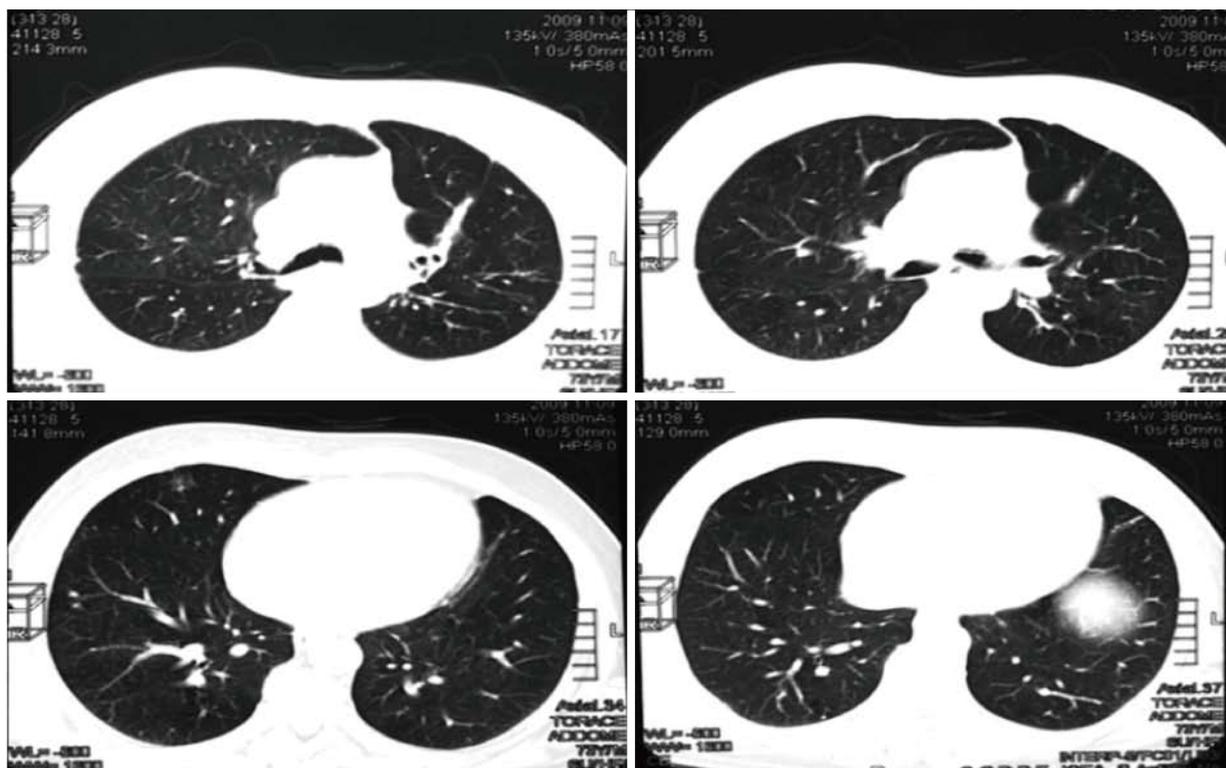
Thorax computed tomography-scan after two months of maintenance treatment. Note a partial regression of disease according to RECIST criteria (September 2009).
